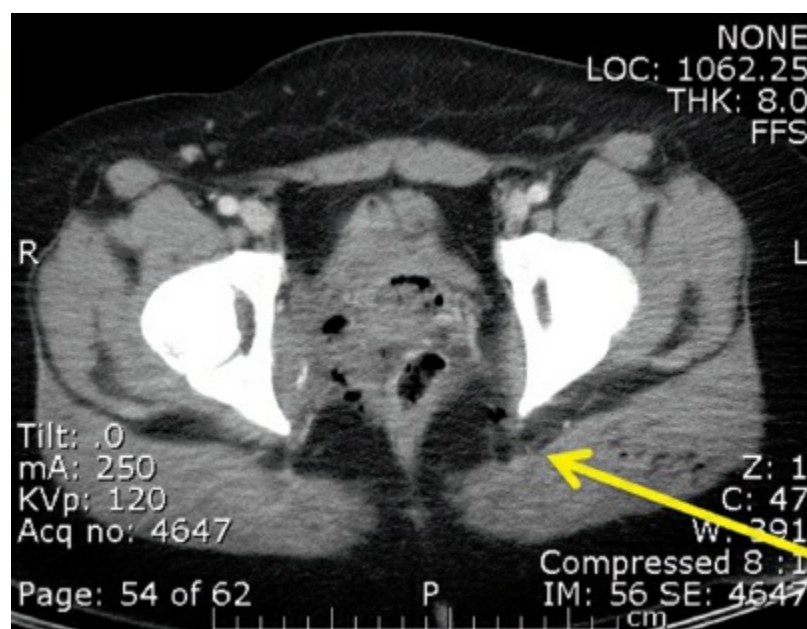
CT demonstrating a gunshot wound tract traversing the rectum, *arrow* demonstrates bullet tract.
